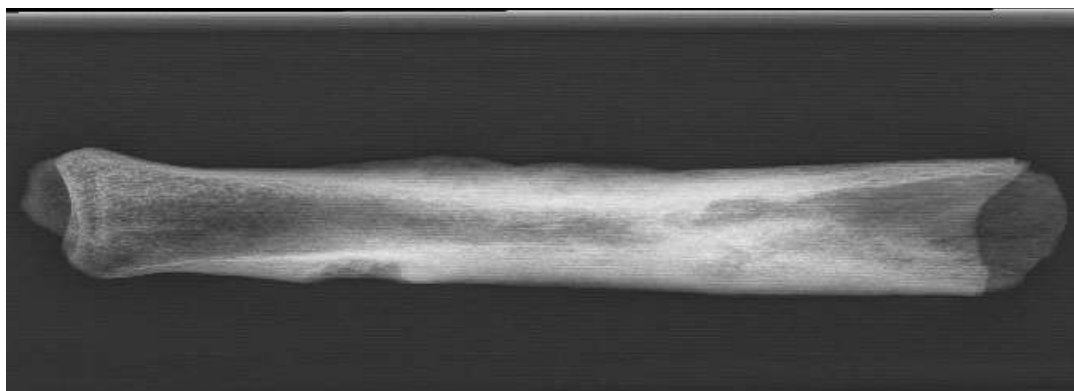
X-ray image of the tibia
